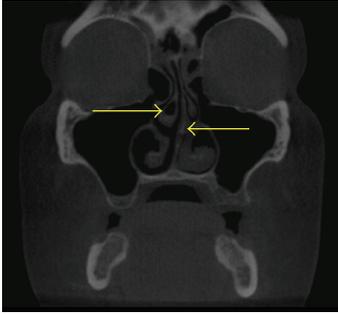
Coronal CT scan demonstrating right middle concha bullosa (left arrow) and left nasal septal deviation (right arrow). No sinus inflammation is present. Also note the differences in shape of the concha: the right middle concha is larger than the left middle; the left inferior concha is larger than the right inferior concha.
